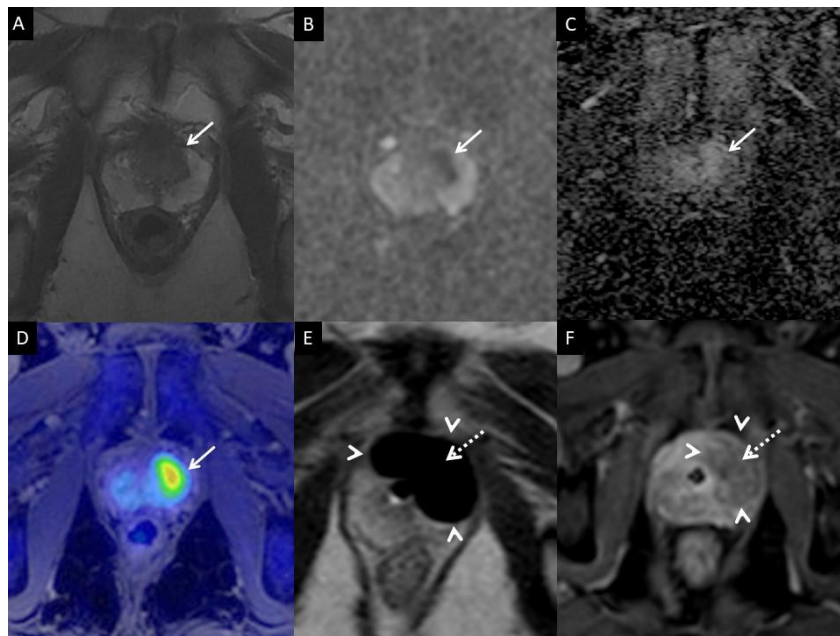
(Cryoablation): 70-year-old male presents with Gleason 3+3 adenocarcinoma of the left anterior prostate with a PSA of 6.2 ng/mL. Multiparametric MRI at 3 Tesla demonstrated an area of decreased signal intensity in the left anterolateral peripheral zone at the prostatic midgland (Panel A, arrow) with corresponding hypointensity on ADC map (Panel B, arrow), and early hyperenhancement (Panel C, arrow). Using a 1.5T MRI, three IceRod cryoneedles were placed via the transperineal approach into the left anterior prostate and freezing was performed under imaging guidance with three freeze-thaw cycles. An iceball is clearly visible on axial T2-weighted image during the freezing phase (Panel D, tumor arrow, iceball arrowheads, urethra dashed arrow). Subsequent post-ablation dynamic gadolinium enhanced series demonstrates the corresponding ablation zone to encompass the previously demonstrated cancerous lesion (Panel E, arrow).
